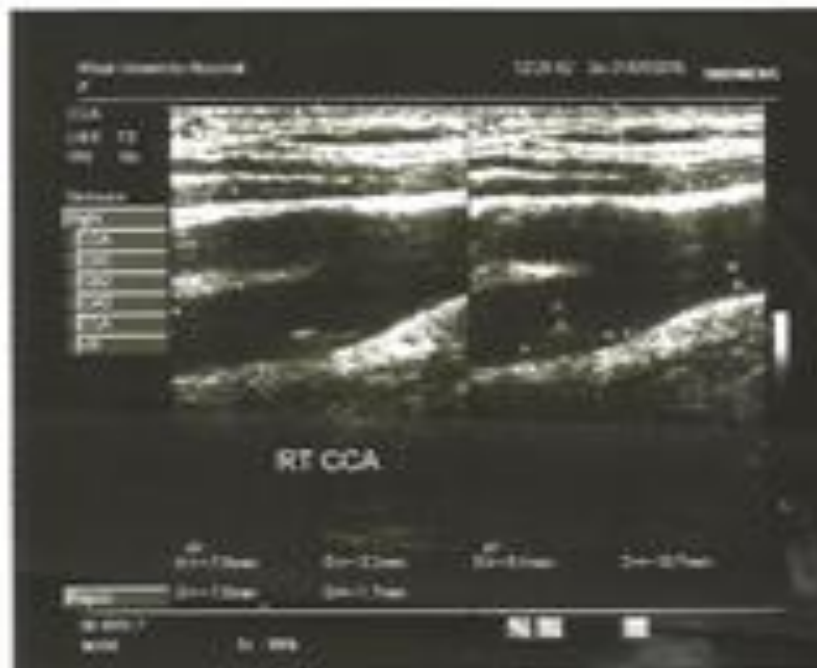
Rt CCA-female- 48 years diabetic patient with normal Doppler parameters.
